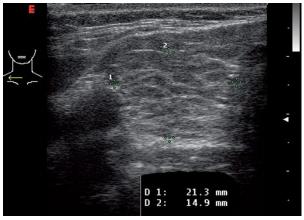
Most biological tissues have varying degrees of inhomogeneity. Connective tissue, blood vessels, and cellular structure all provided mismatches of acoustic impedance that lead to the generation of characteristic ultrasonography patterns.
